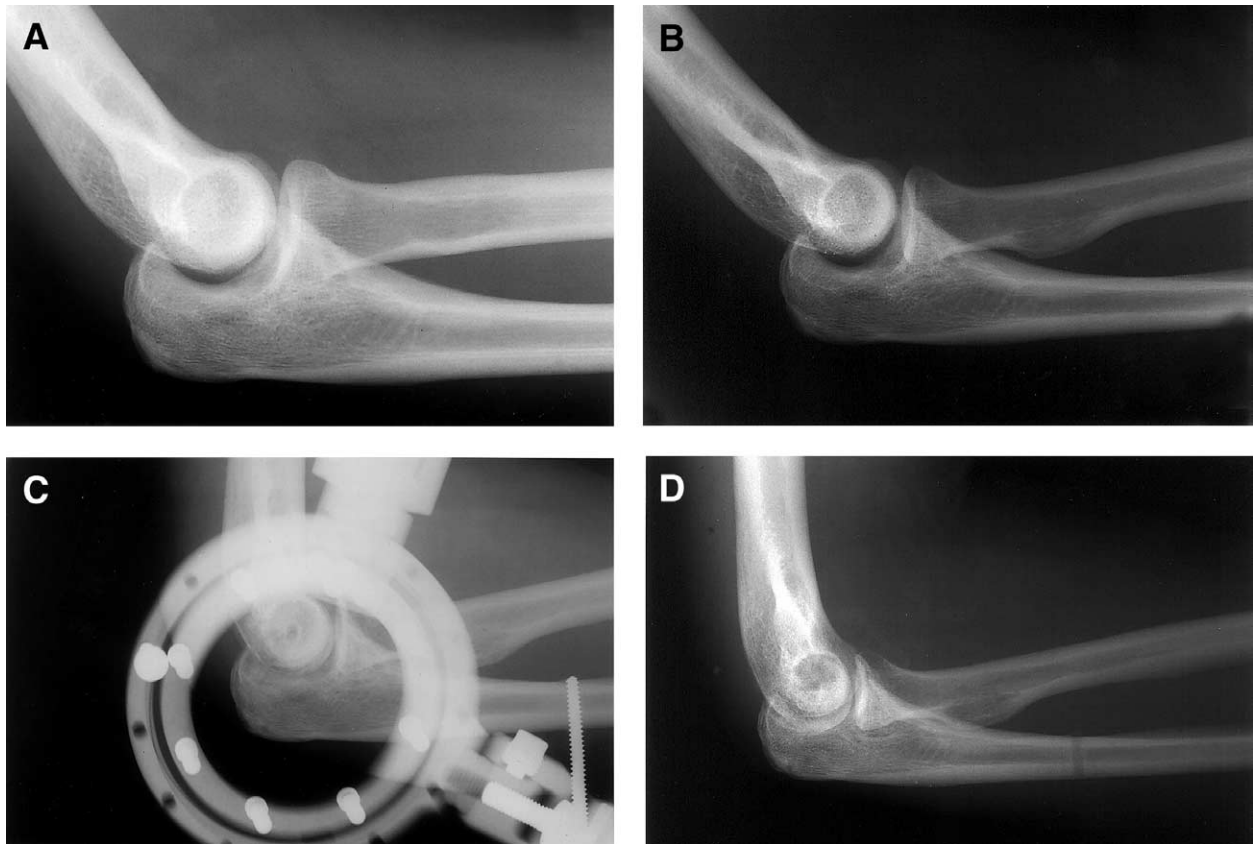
A 24-year-old man fell while playing basketball and sustained a posterior dislocation of the elbow. The dislocation self-reduced (A), and the patient did not undergo immobilization after being seen and was lost to follow-up. At a return visit 4 weeks after injury, gross varus and valgus clinical instability was noted, along with loss of active flexion and extension as a result of pain and subluxation. B, A magnetic resonance image revealed total torn medial and lateral collateral ligament complexes. Open reduction and stabilization with a dynamic external fixator were carried out (C), and after 4 weeks of stabilized motion in the fixator, the range of motion was 35° to 135° (D). A drop sign was noted (A and B).
